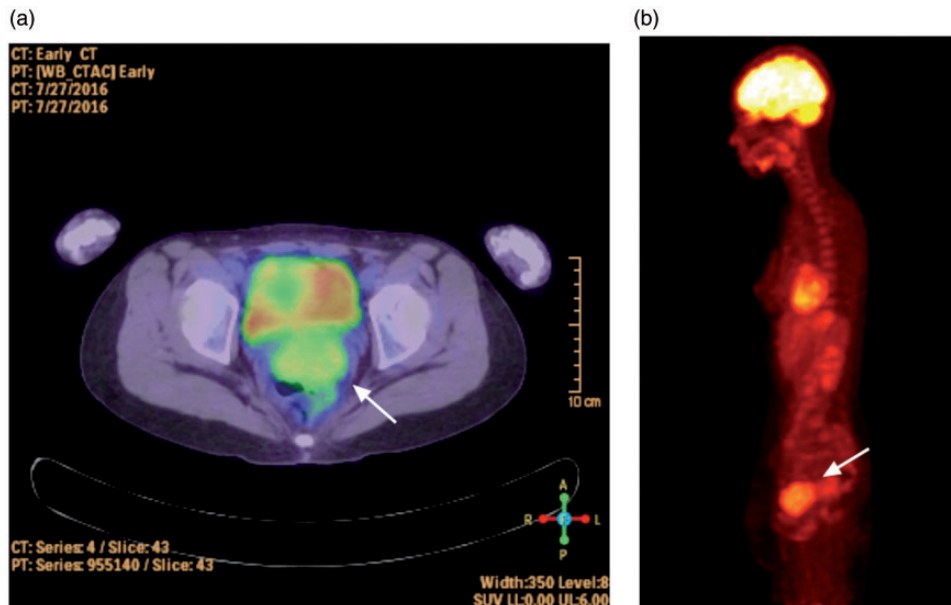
^{18}F -FDG PET/CT: (a) axial PET/CT, (b) lateral MIP image. Homogenous uptake was observed in the PET/CT images with maximum standardized uptake value (SUVmax) of 3.78. No distal lesion was observed.
